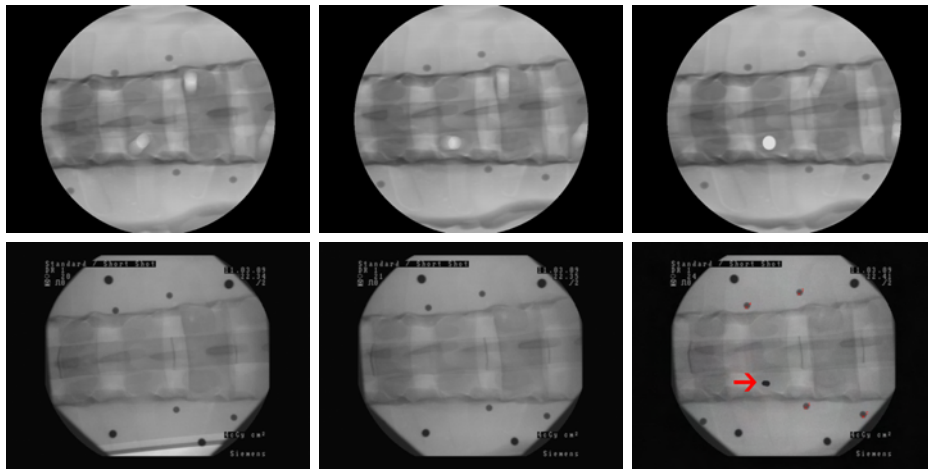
The upper row shows generated DRRs, the lower row shows corresponding X-ray images; The first column shows the starting position after registration, followed by an intermediate shot during positioning. The right column shows the final position. Note that the righthmost X-ray was taken after the actual drilling, with a metal pin inserted into the drill hole for better contrast. Image courtesy of Philipp Dressel [150].
